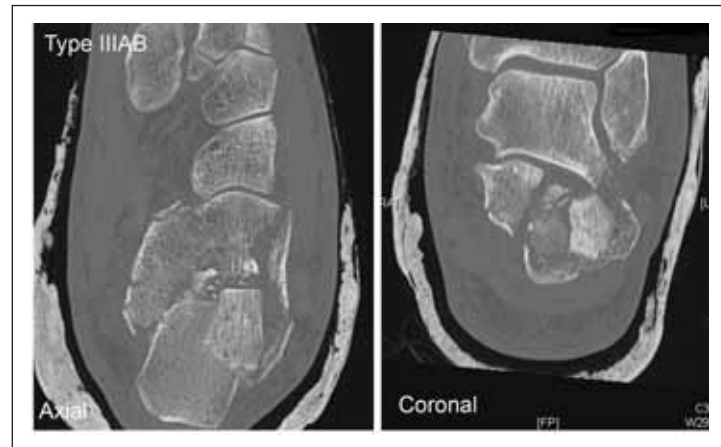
Axial and coronal CT scan images of Sanders Type IIIAB fracture.
